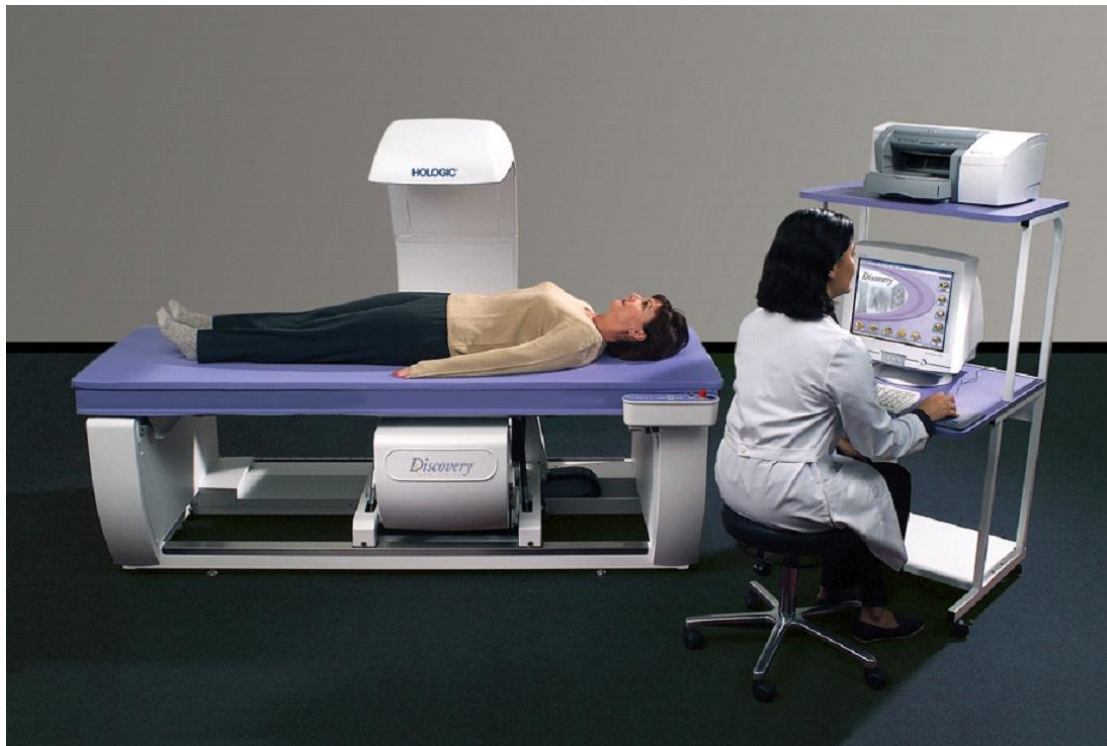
An example of an x-ray machine to measure bone density at central skeletal sites.
